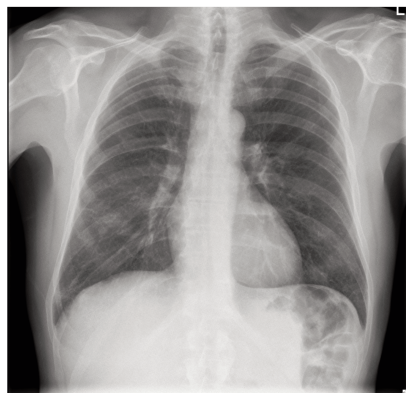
Chest x-ray showing an accentuation of interstitial plot at the right lower lobe.
